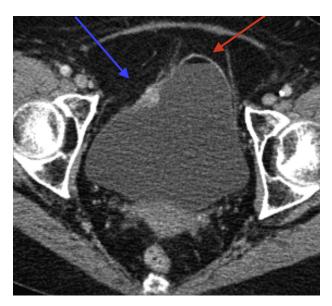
Development of an intravesical fat-fluid level (red arrow) and appearance of fat necrosis (blue arrow) approximately 8 months following the initial post-operative CT scan.
